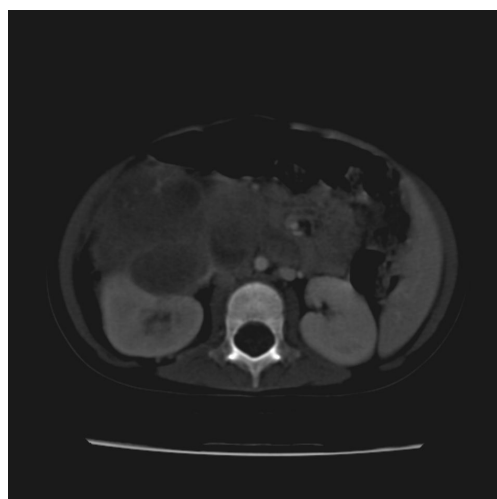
Example of 2D CT image of human body.
